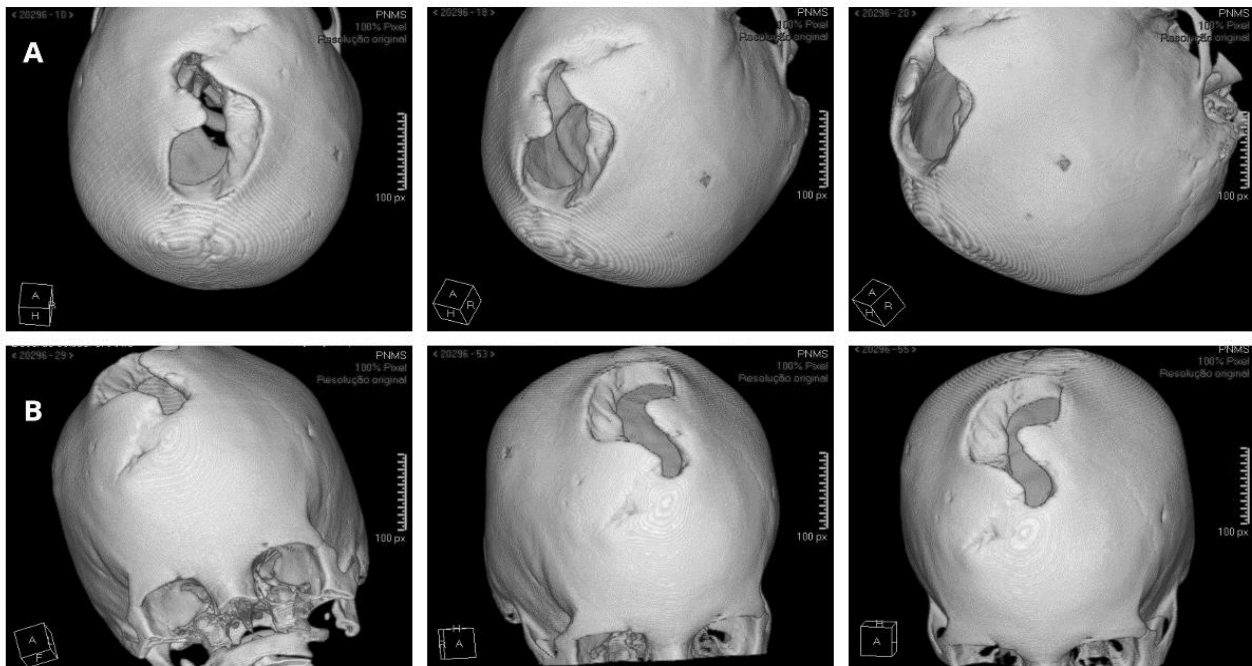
Sequences A and B are computed tomography scans of the skull with 3D reconstruction showing the absence of bone fusion of the anterior fontanelle.
